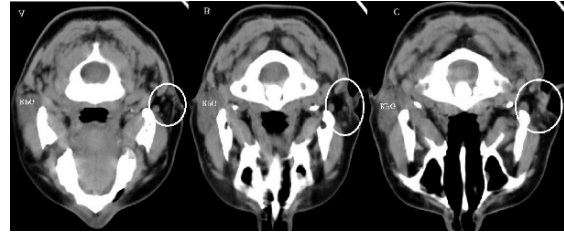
Non-contrast-enhanced CT of the neck: A right parotid gland (RPG) with preserved anatomical configuration and attenuation characteristics is demonstrated. In contrast, the left parotid fossa shows absence of identifiable glandular parenchyma, consistent with congenital parotid agenesis (circle). Axial CT sections depict the parotid region at inferior (A), mid-gland (B), and superior (C) levels.
